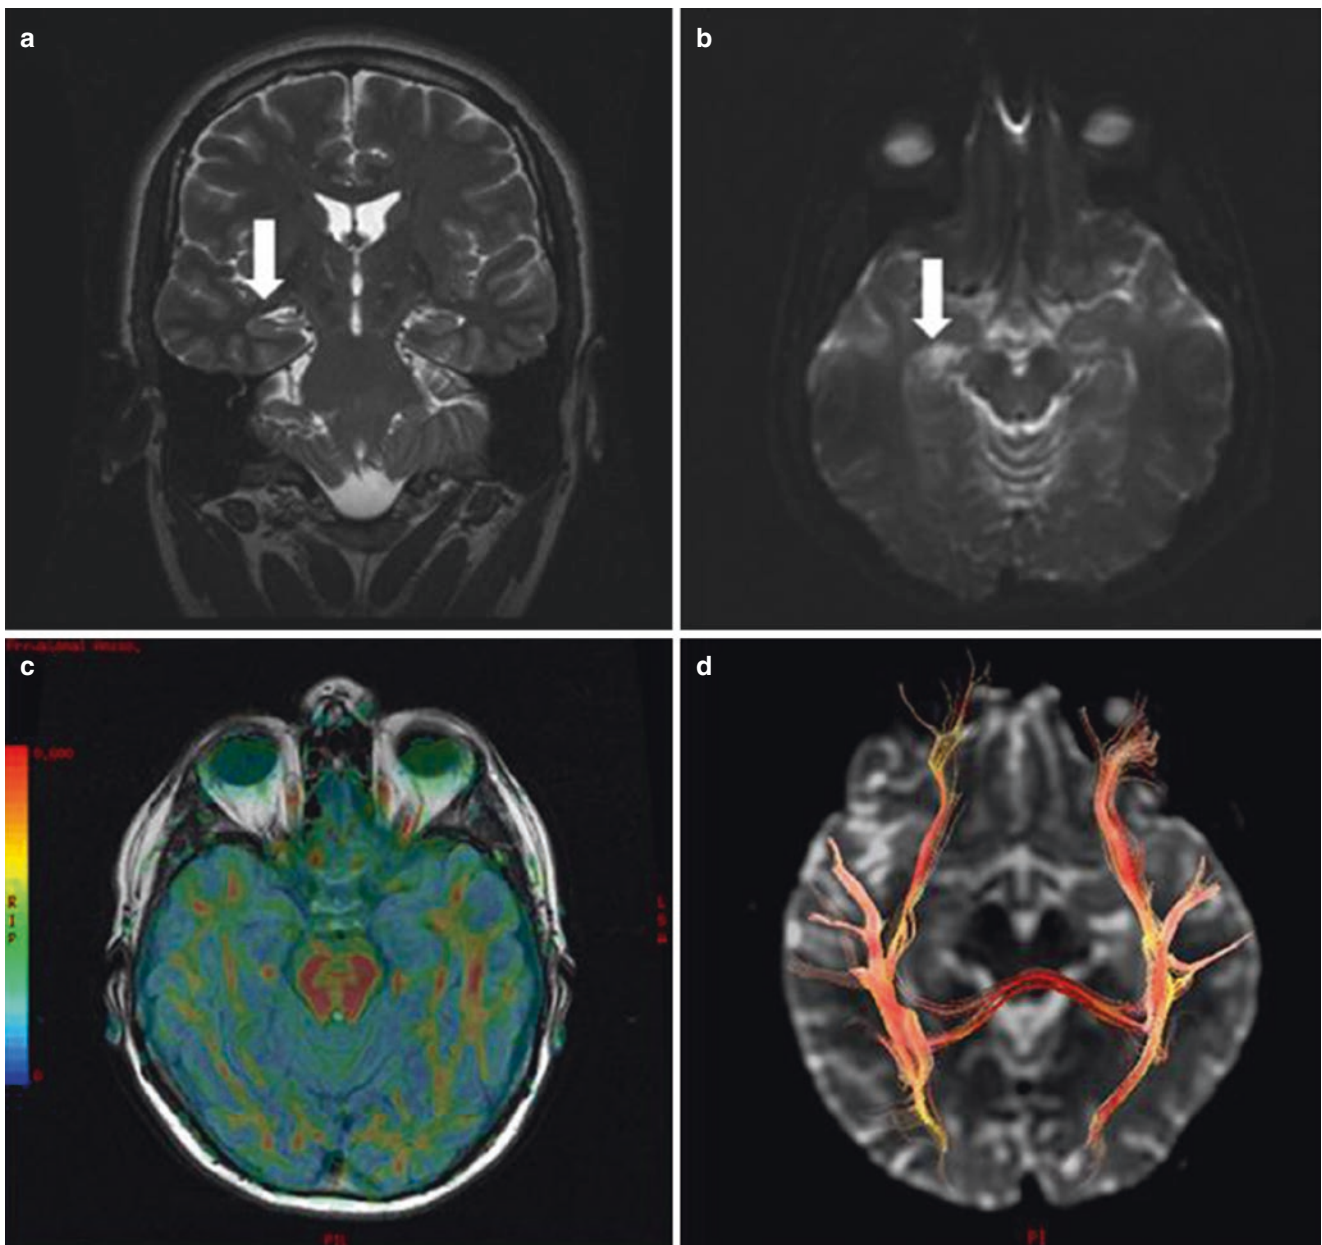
(a) High resolution T2-weighted image; (b) Apparent diffusion coefficient map; (c) FA map; (d) Tractography in a patient with hippocampal sclerosis
